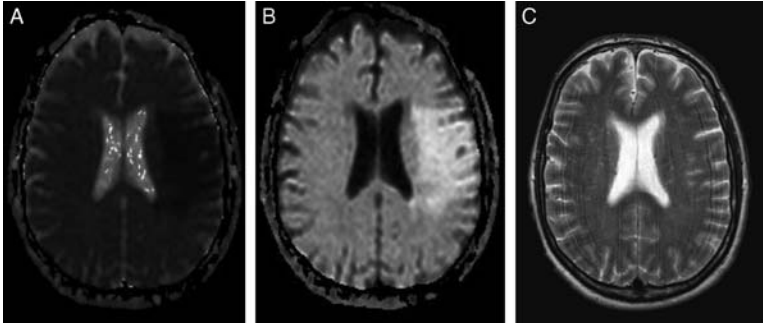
Acute stage of left medium cerebral artery ischemic stroke: as shown on the images, the ischemic acute stage is visible on DWI-weighted images earlier than on conventional MRI: (A) ADC (B) eADC, and (C) conventional T2-weighted MRI scan.
